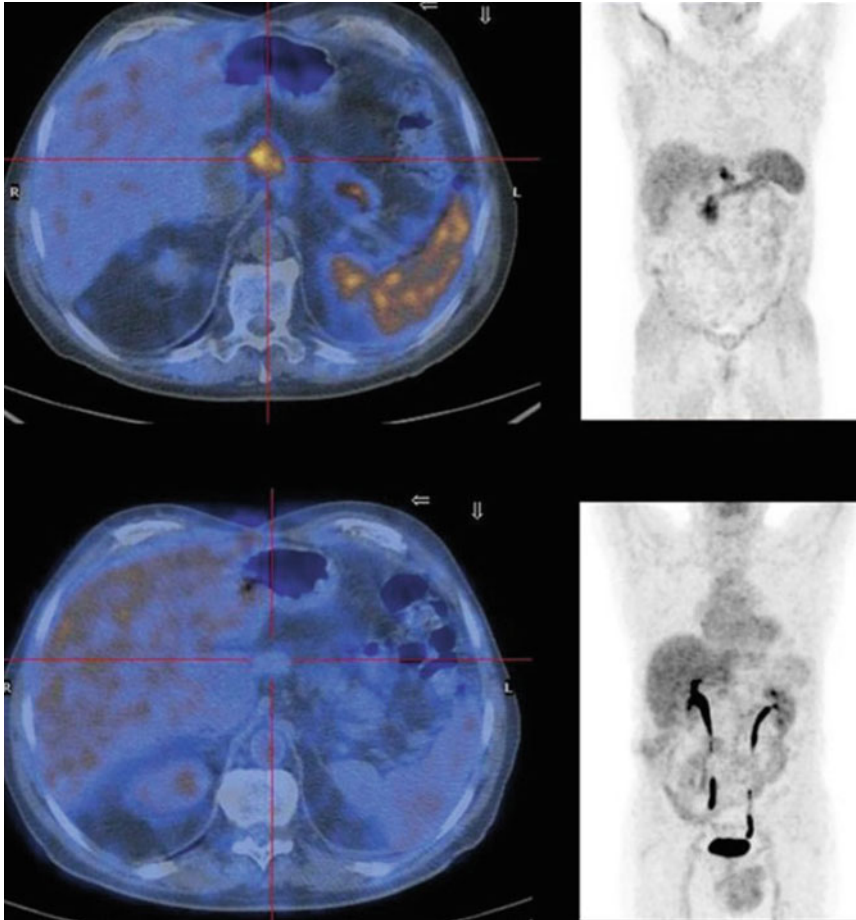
MIP images of a nodal recurrence of HCC studied with ^{11}C -Acetate PET/CT (upper view) and ^{18}F -FDG PET/CT (lower view); FDG-PET shows no pathology uptake, while Acetate-PET clearly detects nodal involvement
